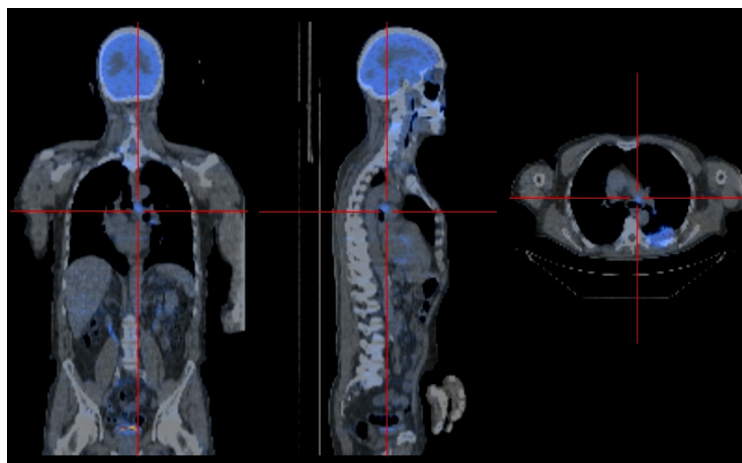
Fused PET and CT coronal, sagittal and transaxial slices taken using the Hybrid PET/CT, Discovery LS from GE Medical systems (courtesy of GE Medical Systems).
